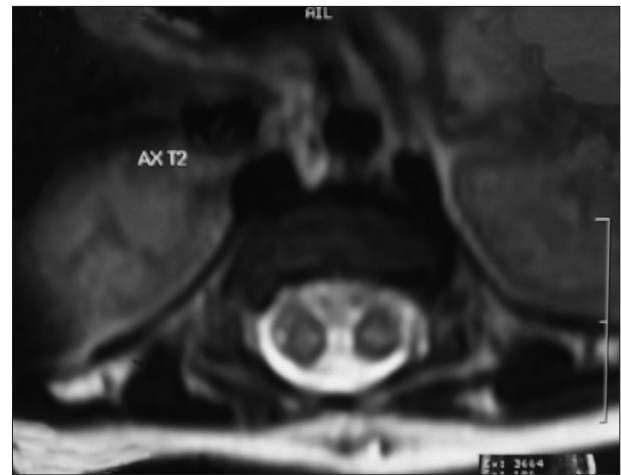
MRI spine (axial view) showing two hemicords separated by spur
